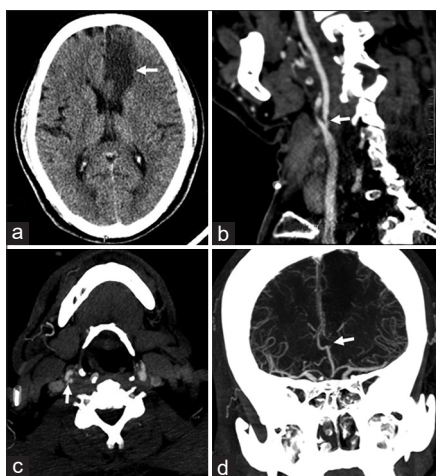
CT brain with angiogram of the patient. (a) Axial CT brain on admission showing left mesial frontal hypodensity (arrow) suggesting an evolved ACA territory infarct. (b) CT angiogram of extracranial vessels in sagittal section showing right proximal (white arrow) ICA plaque causing 80% stenosis. (c) CT angiogram axial section at the level of carotid bifurcation showing hypodense plaque (white arrow) in the right proximal ICA. (d) CT angiogram coronal section of intracranial vessels showing azygos ACA and left division occlusion (arrow)
